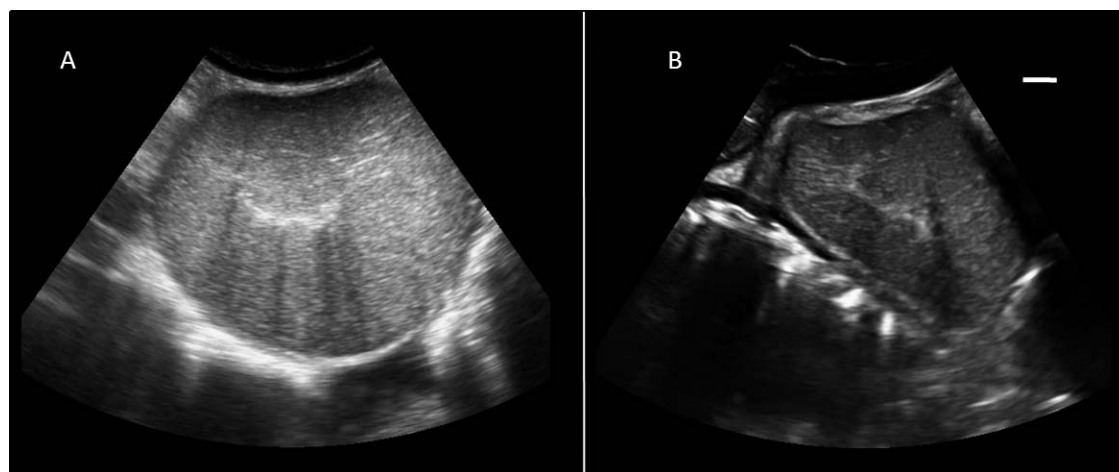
Ultrasound image of the right testicle of bull 1. A. Prior to GnRH vaccination, the testicle appeared round and firm and measured 8.5×10.2 cm. B. Two years after treatment, the right testicle was markedly smaller (5.3×7.5 cm) and softened, indicated by the amorphous shape when pushed against intestinal loops. Bar = 1 cm.
